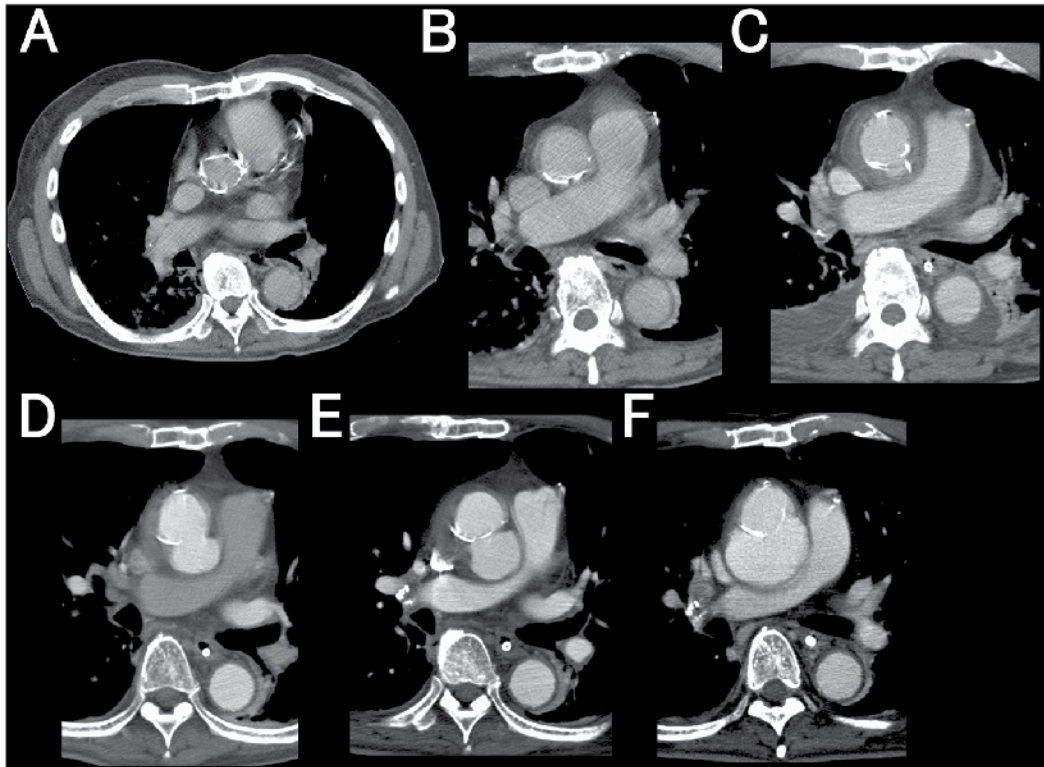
A case of medical treatment of an infected aneurysm. A 75-year-old man with familial hypercholesterolemia, cerebral infarction, and coronary bypass grafting presented with high fever and chest pain. Panel A and B showed a severely calcified ascending aorta. The repeated CE-CT on the 5th day revealed aneurysmal change with protrusion (Panel C), indicating an infected aneurysm. Due to a prohibitive risk of surgery, medical treatment was the choice of him and his family, but the infected aneurysm gradually enlarged despite the control of bacteremia with antibiotics (13th day: Panel D, 24th day: Panel E, and 58th day: Panel F), and he died 2 months after onset.
